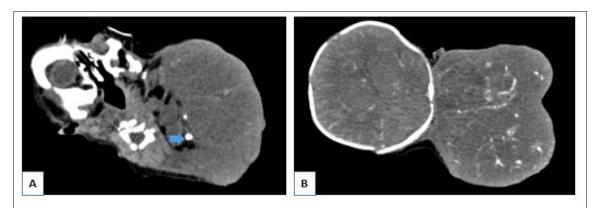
CT scan of the neck without (A)and after injection of contrast product (B) showed dystrophic calcification (blue arrow) and a large area of fat with enhancement of the tissue portion. This masse is extended to the ipsilateral scalp.
